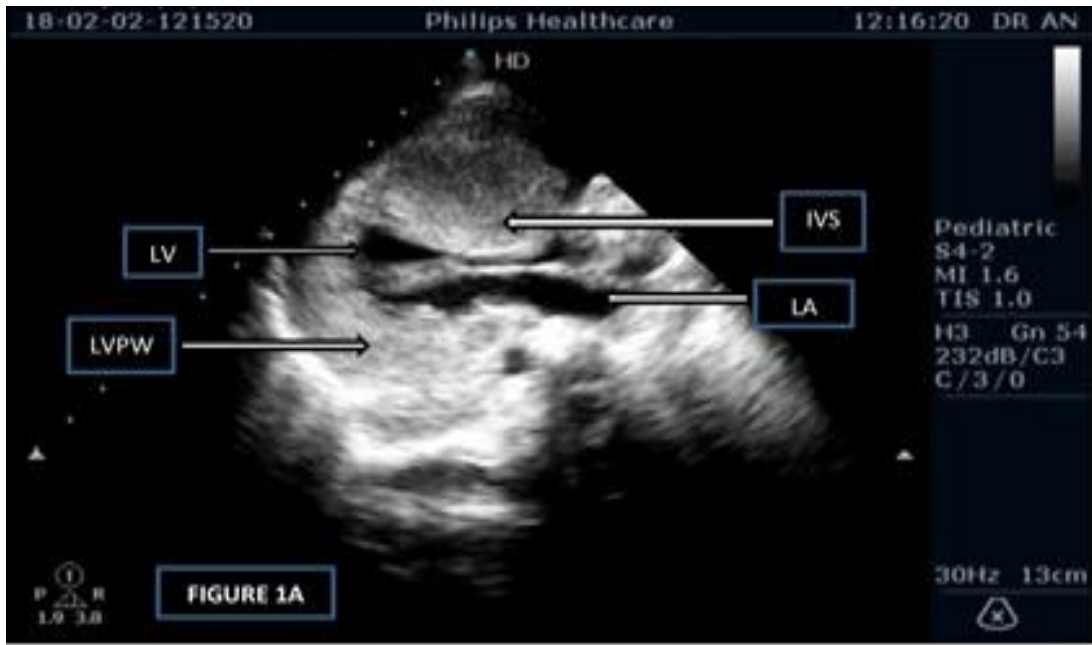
Parasternal long axis view showing severe concentric hypertrophy of left ventricle without left ventricular outflow tract obstruction. LV: Left ventricle, LVPW: Left ventricular posterior wall, IVS: Interventricular septum, LA: Left atrium.
